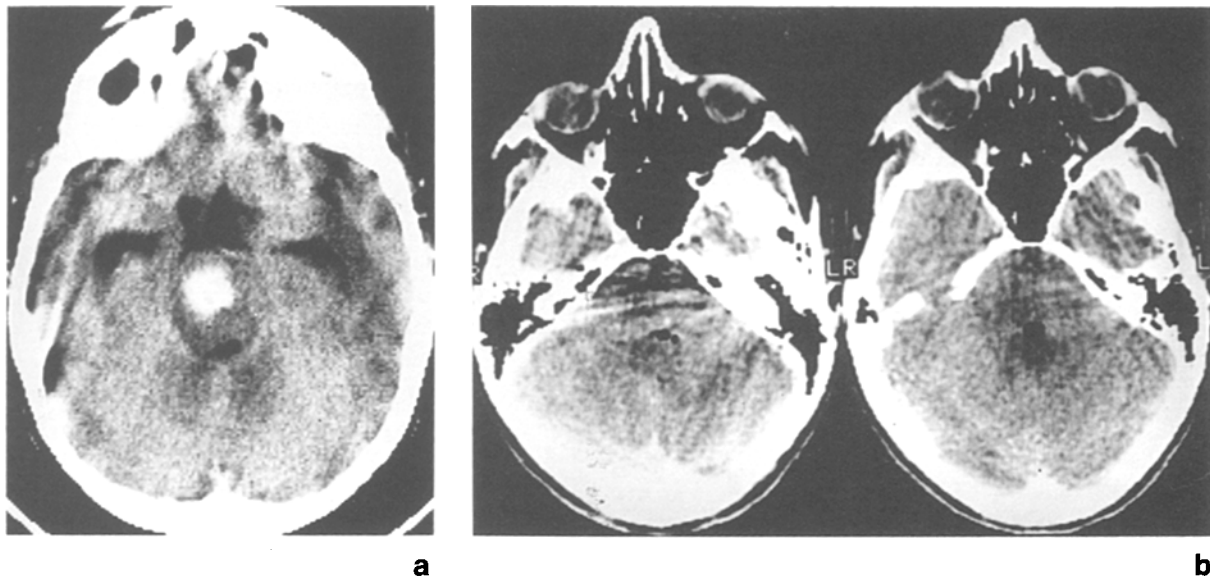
Pre-operative (a) and post-operative (b) CT scans of the same patient (case 1). Stereotactic aspiration of the haematoma resulted in complete neurological recovery. The post-operative scan shows some air in the cavity but no residual haematoma
